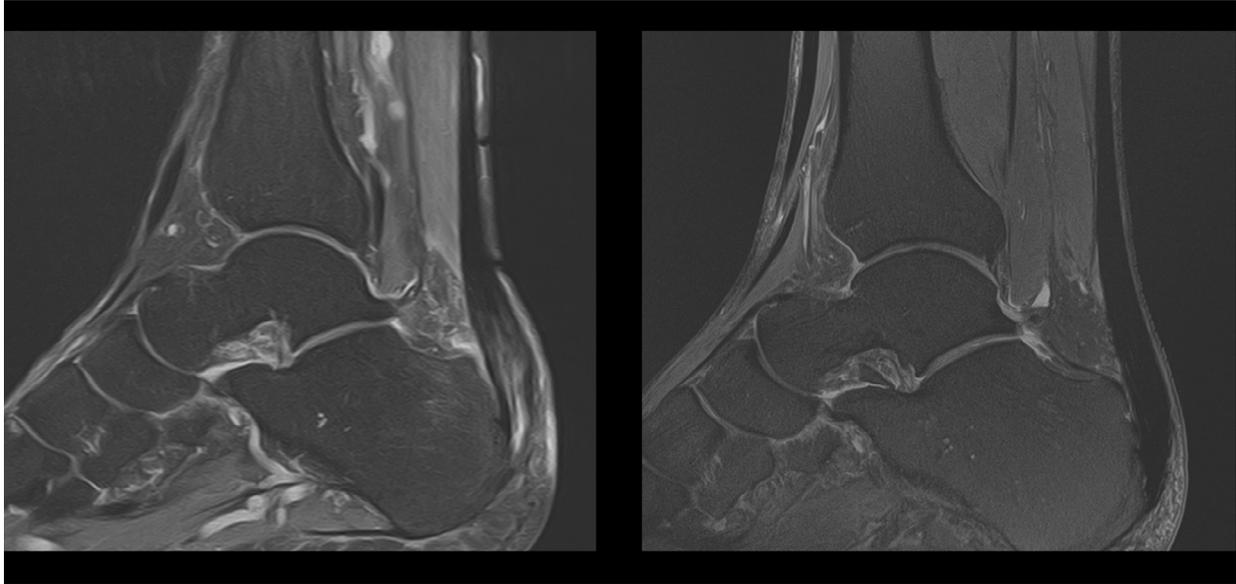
(Case 3): A 52-year-old patient with a surgical infection and a 2.5-year history of chronic partial rupture of the Achilles tendon in the left ankle. The patient had previously undergone debridement, removal of the surgical material, and endovenous antibiotic treatment. Six months later, the patient received aBM-MSC treatment. A) T2-weighted magnetic resonance imaging (MRI) before local autologous bone marrow mesenchymal stem cell (aBM-MSC; 20×10^6 cells) injection. Presence of tissue 33.3%. B) T2-weighted MRI at 12 months post-aBM-MSC injection. Complete regeneration of chronic partial Achilles tendon rupture (100%) was achieved. No adverse events. The patient resumed padel tennis after four months.
